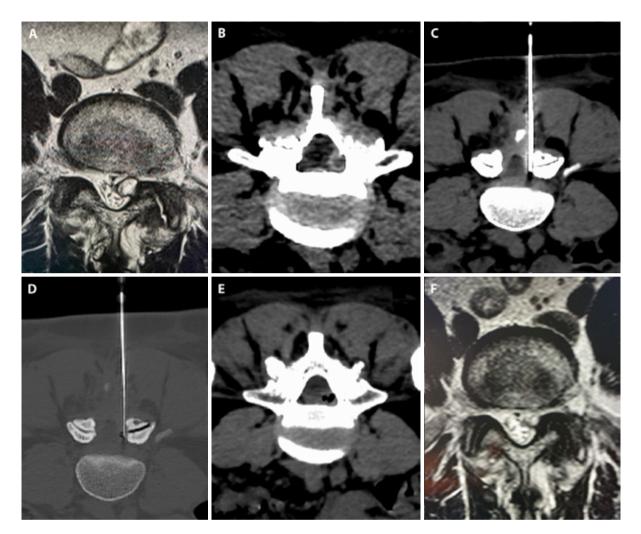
A: MRI T2W axial plane showed a large synovial cyst on the left zygapophyseal joint. B: Axial CT scan of the same cyst, with thickened walls, due to chronic nature of the pathology. C-D: Intra-procedural CT scan showed the correct positioning of the 22G needle inside the cyst. E: CT control scan after O2\O3 injection; the leakage of the gaseous mixture outside the cyst is noticeable. F: control MRI images demonstrate a shrinkage, with significant reduction of painful symptoms.
